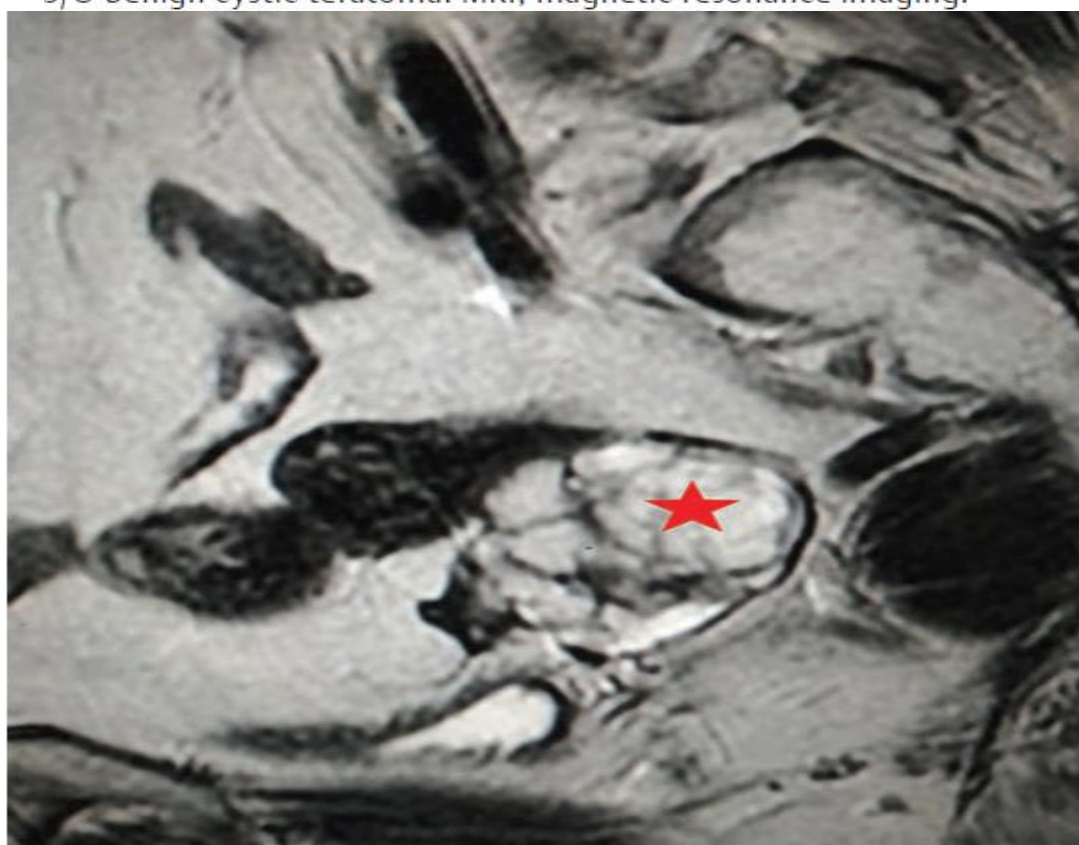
Sagittal T2-W MRI demonstrating a well-defined multiloculated heterogeneously hyperintense cystic lesion (star) in the right adnexa. Right ovary is not visualized separately from the lesion, features are of concern for malignant ovarian etiology. MRI, magnetic resonance imaging.
